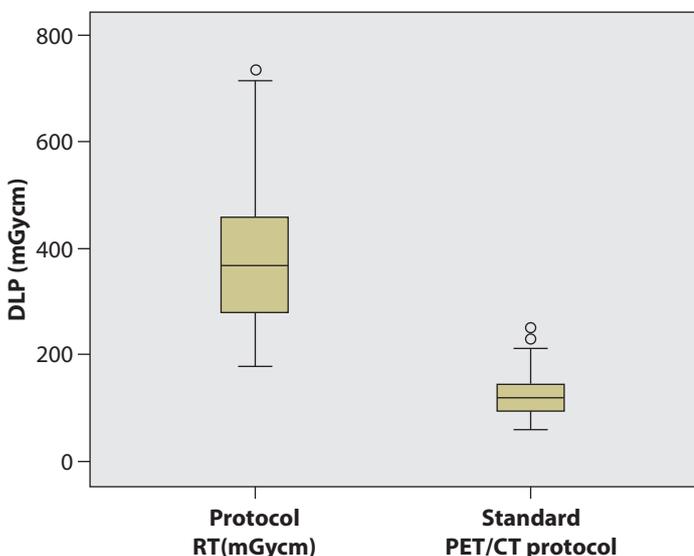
Comparison of the DLP on the lung in the radiotherapy (RT) and standard PET/CT protocols
